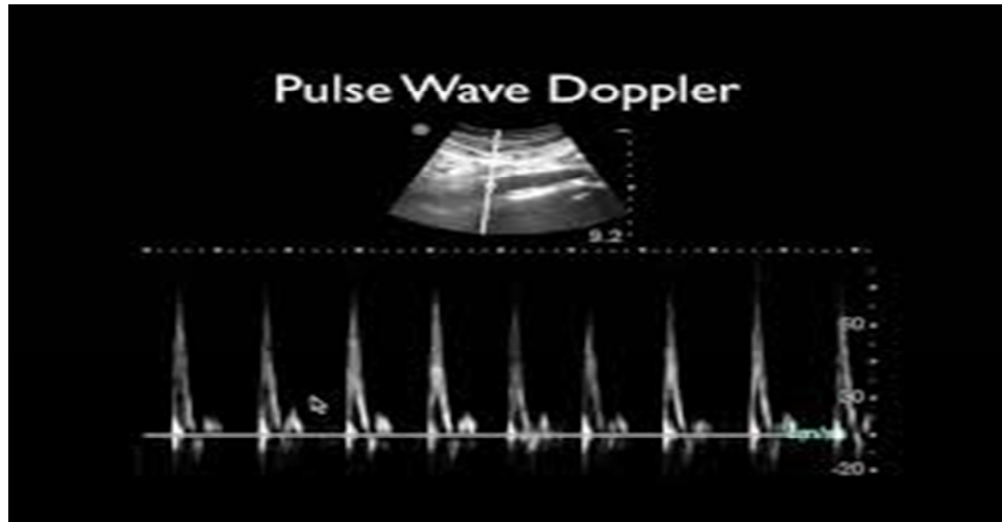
PULSE WAVE DOPPLER IMAGING
